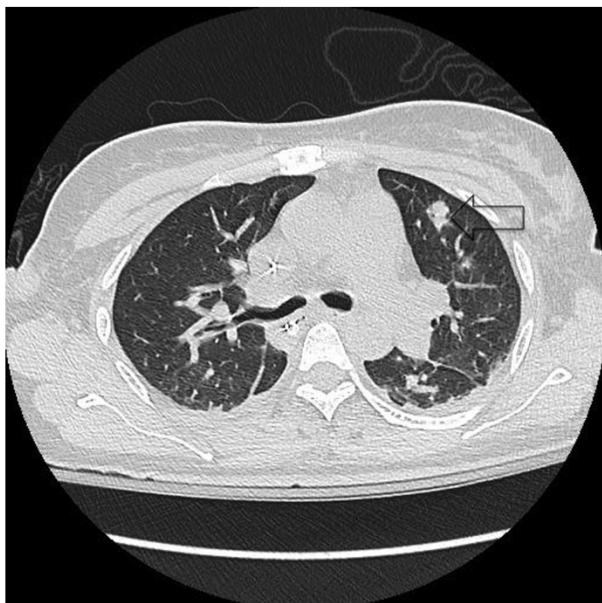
Computed tomography scan of the chest demonstrating noncalcified pulmonary nodule (open arrow).
